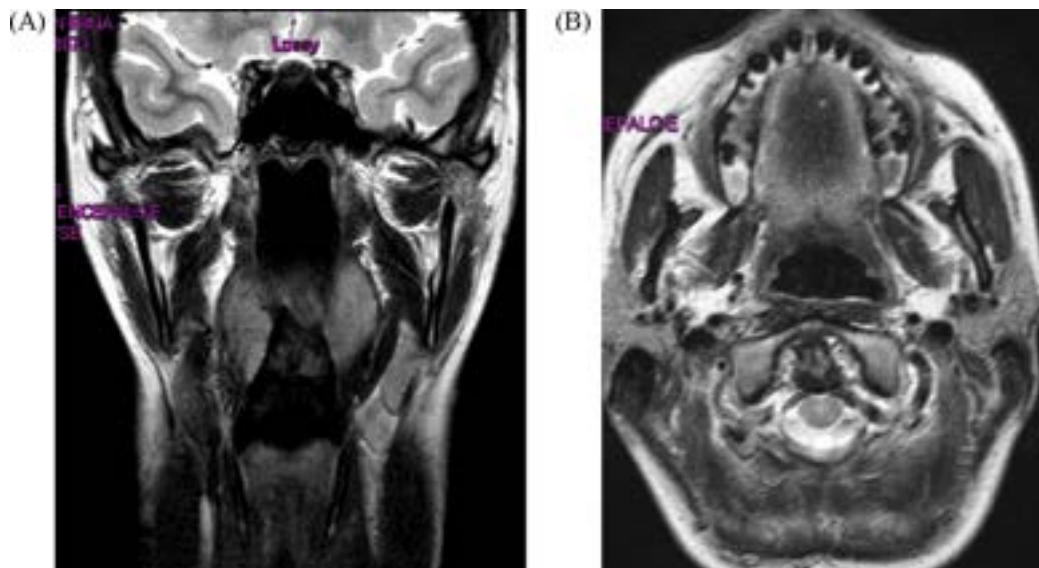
Postoperative T2 MRI: coronal (A) and axial (B) showing complete tumor removal and patient to be disease free.
